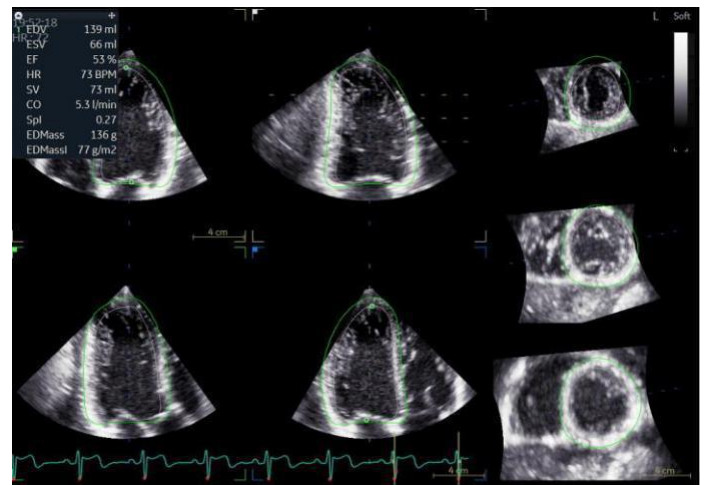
2D Echocardiography with measured parameters at the bottom of the recesses
